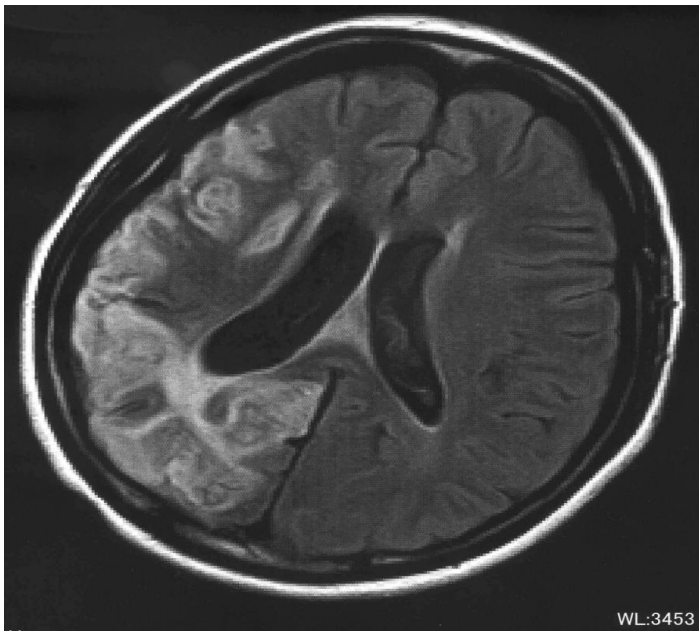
Ischemic changes in the temporal and occipital regions match the perfusion sites of the right middle and posterior cerebral arteries on cranial magnetic resonance imaging.
